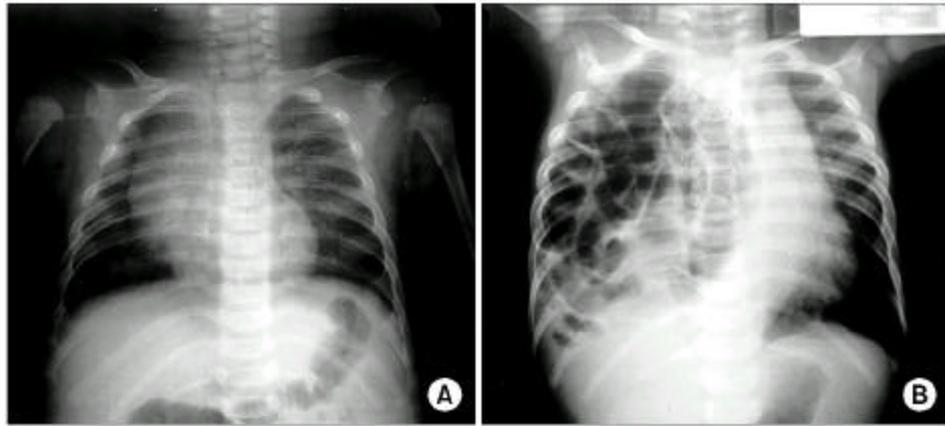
Same infant with normal x-ray at 3 months (A) and right congenital diaphragmatic hernia at 11 months (B) (case 2).
